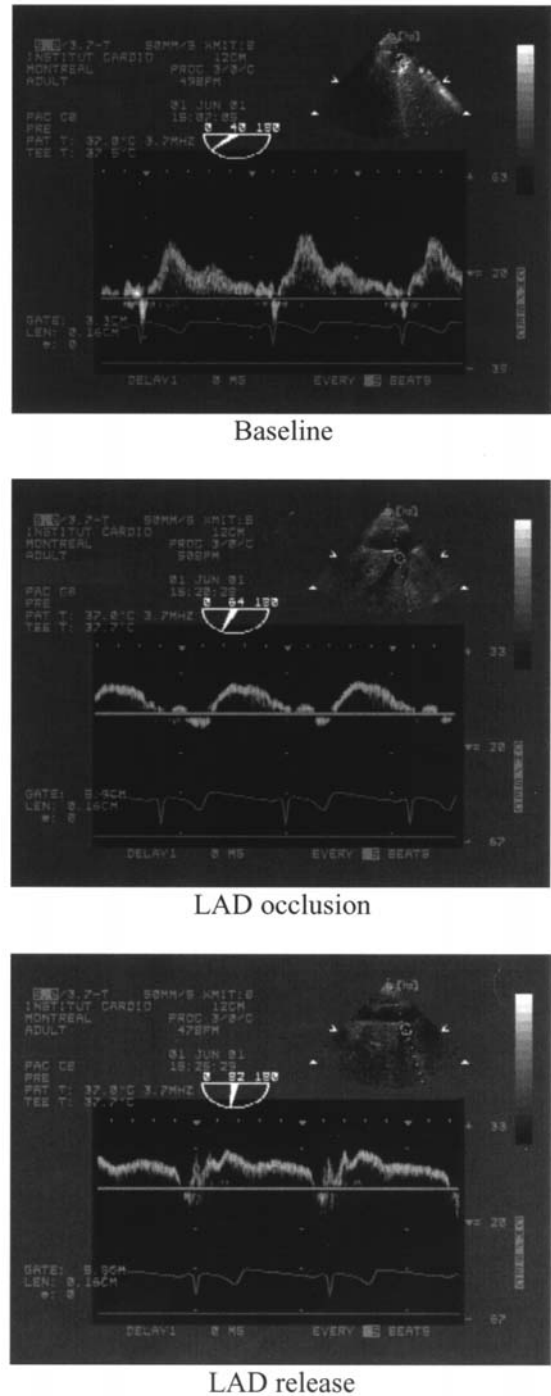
Hepatic vein Doppler signal at baseline, following left anterior descending (LAD) occlusion and release. During LAD occlusion, a reversible restrictive pattern on the hepatic vein Doppler signal appears with a reversal of the S wave signal, which suggests a right ventricular compression.
